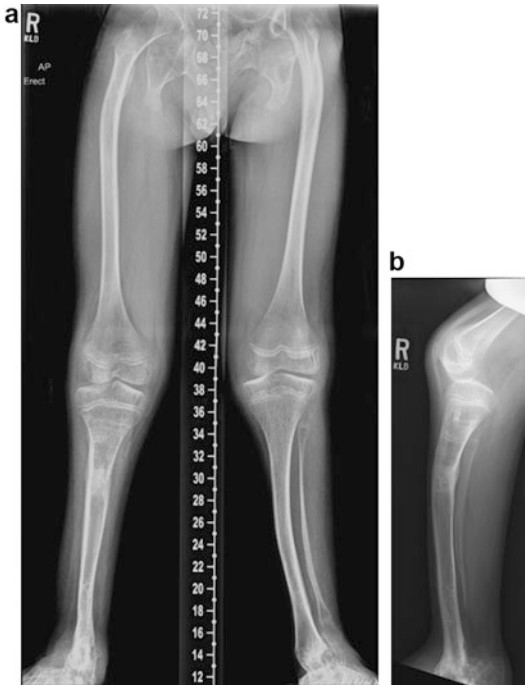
A 13-year-old male was diagnosed to have camptomelic dysplasia shortly after birth. According to the mother, the diagnosis was confirmed by the genetic testing. The radiography of bilateral lower extremities demonstrated bilateral hip dislocation. There was generalized osteopenia. The femurs were mildly bowed laterally, but appeared normal. The tibiae were shortened and thin bilaterally with medial bowing on the left (a). Lateral view of the right tibia (b) showed mild anterior bowing of the tibia and partial deficiency of the distal right fibula. There was fusion of the ankle joints bilaterally. Sclerotic focus identified in the proximal third of the right tibial diaphysis corresponds to a healing lengthening osteotomy. Diffuse muscular atrophy was present (Courtesy of Dr. Grace Guo)
